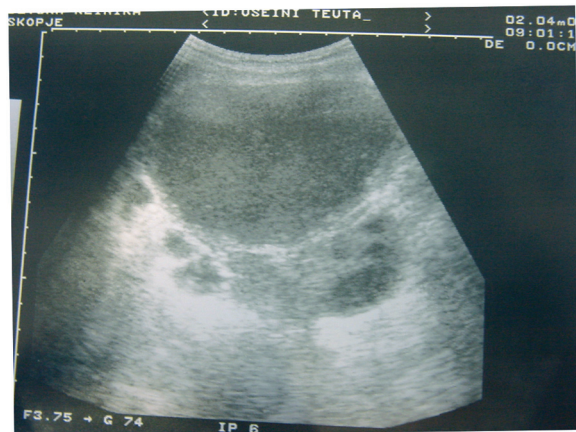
Ultrasound examination demonstrated a large unilocular cystic mass
